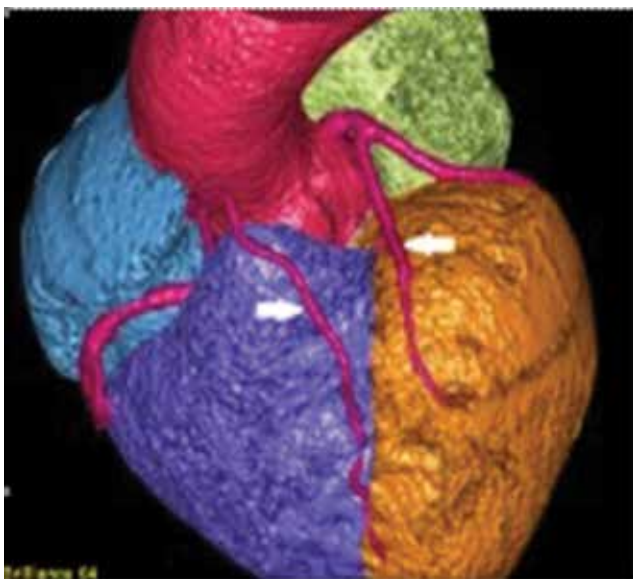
Multislice computed tomography (MSCT) of coronary arteries. The short left anterior descending (LAD) from the left main coronary artery, coursing through the proximal anterior interventricular septum (right white arrow) and the long LAD artery from the right coronary artery coursing along the distal anterior interventricular septum (left white arrow).
